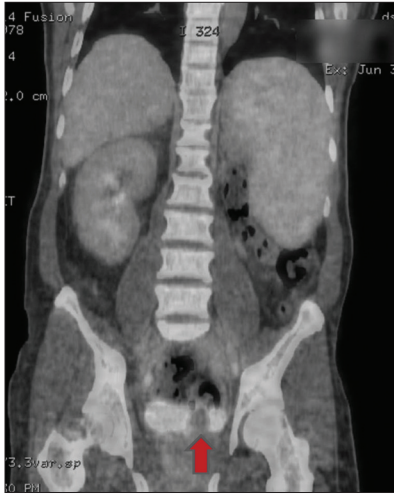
F-18 FDG PET/CT study, showing coronal section of abdomen and pelvis. The scan shows an enlarged spleen with relatively more FDG uptake than the liver. In addition, there are metabolically active inguinal, iliac, periaortic, prevertebral lymph nodes, as well as increased bone marrow activity. The left kidney is absent with compensatory hypertrophy of right kidney
